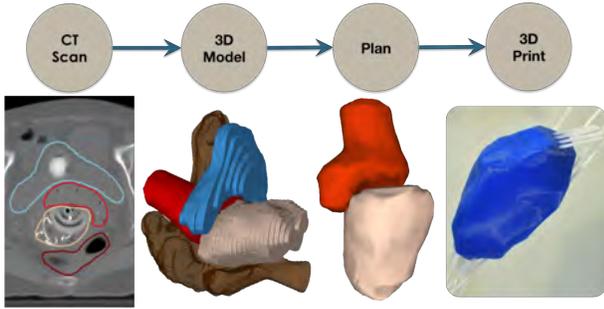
The sequence of figures depicts the proposed procedure for creating a custom implant. A CT-Scan is used to generate 3D models; which are smoothed to get mesh models, and used for treatment planning and internal channel planning in cavity. Thereafter, a cavity conformal implant is created using 3D printing as shown
